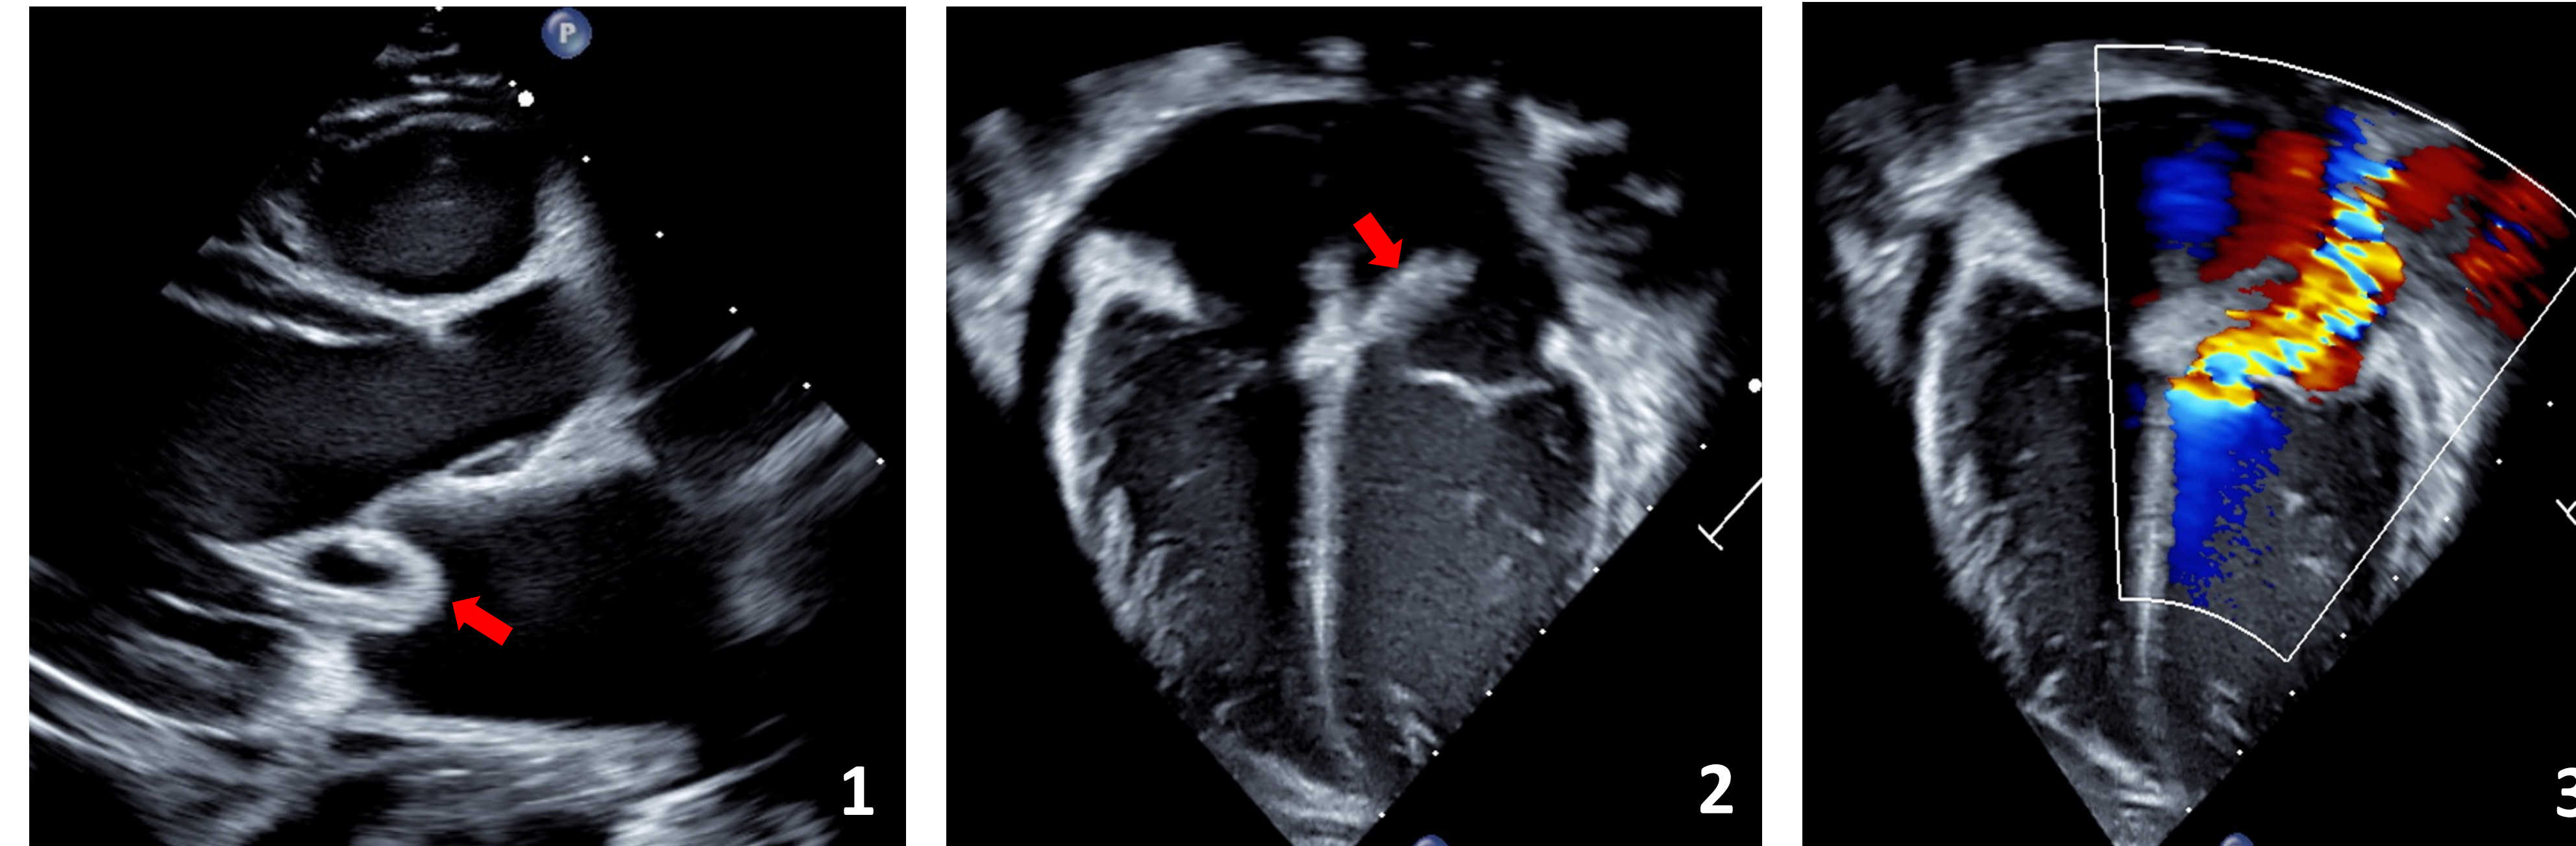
A pedunculated hypermobile mass (red arrow) is seen on parasternal long-axis and 4-chamber views attached to the anterior leaflet of the MV suggestive of vegetation
